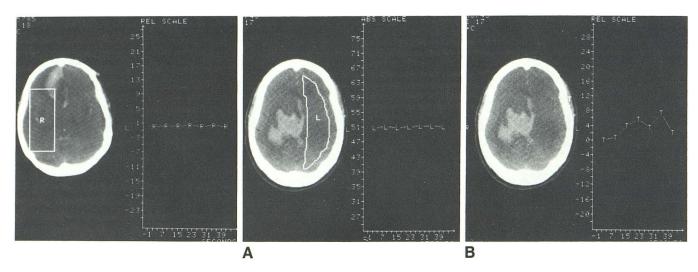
Hypertensive intracerebral and intraventricular hemorrhage. No change in CT numbers indicating absent blood flow.
